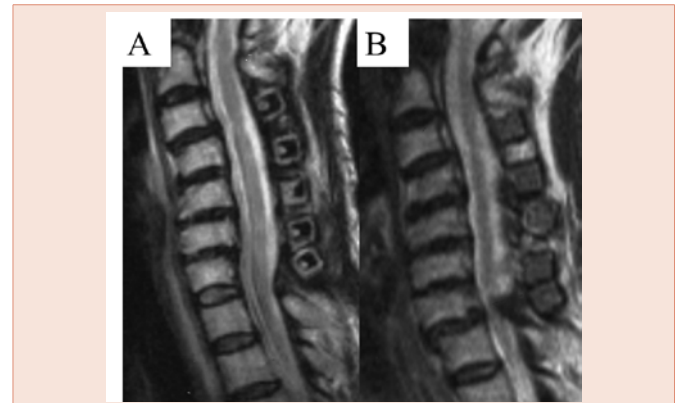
MRI T2-weighted sagittal image one month (A) and 11years (B) after C3-7 laminoplasty (original surgery).
